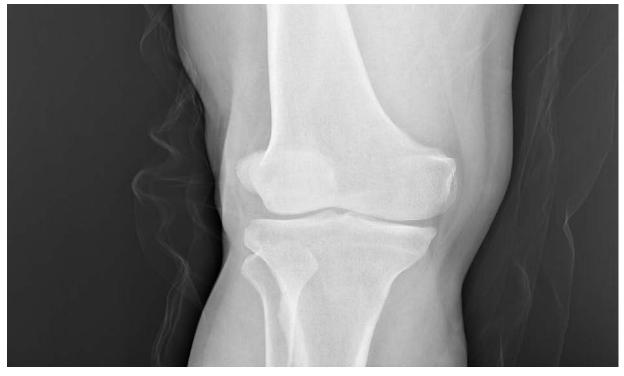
Antero-posterior X-ray of the knee
